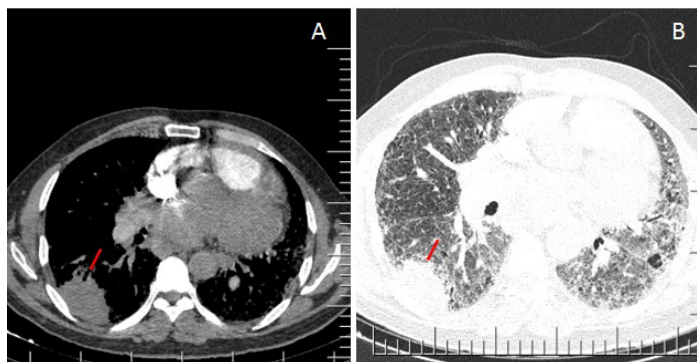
A 72-year-old man with non-interstitial pulmonary fibrosis interstitial lung disease and pathologically confirmed diagnosis of small cell lung cancer A-B: Axial high resolution CT image obtained at the level of the lung base shows ground glass opacity and reticular densities. Axial high resolution CT and mediastinal window image show a mass with soft tissue density at the periphery of the right lower lobe (open arrow).
